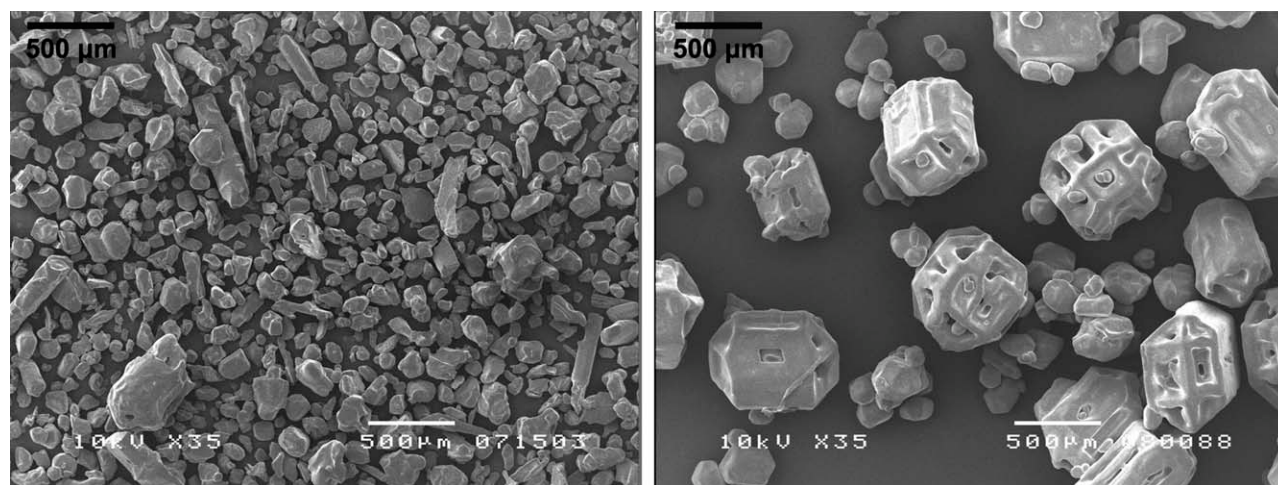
SEM pictures of crystals produced in vessel A with effective ultrasound (left, experiment A2) and from vessel B with ineffective ultrasound (right, experiment B2).
